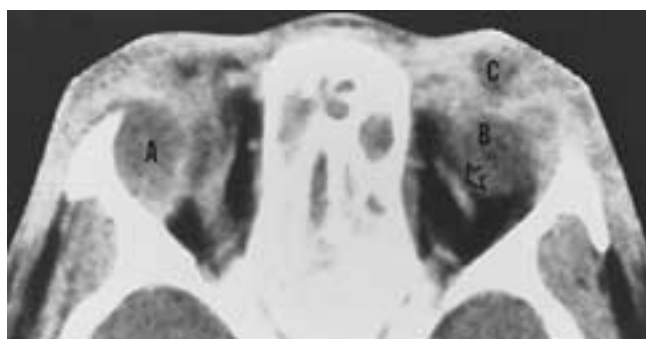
Orbital cellulitis and abscesses. CT scan shows right periorbital cellulitis and three abscesses. (A), Right retroseptal abscess. (B), Left retrobulbar abscess. (C), Left eyelid abscess. Note slightly engorged left superior ophthalmic vein (hollow arrow).
